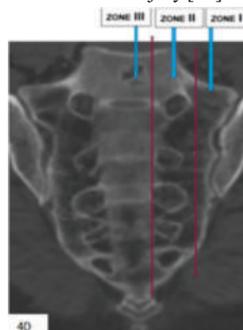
CT bone window oblique coronal image demonstrating of types of sacral fracture according to Denis classification.
